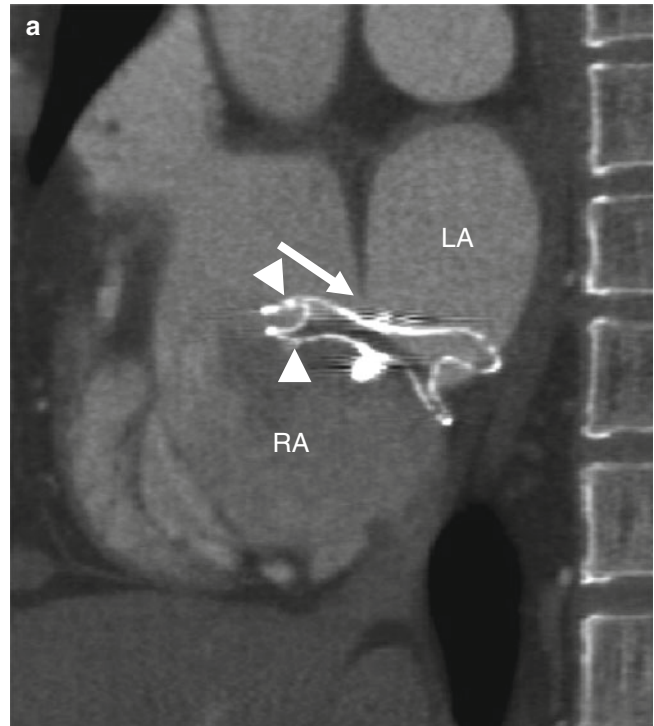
Malpositioned occluder. Minimal device protrusion is noted due to rim deficiency but no residual shunt is present. This oblique, sagittal image shows the upper portion of the AMPLATZER septal occluder device protruding into the right atrium (*RA*). Both left and right atrial disks (*arrow*) are in the right atrium. *IVC* inferior vena cava, *LA* left atrium, *SVC* superior vena cava (Reproduced with kind permission of the American Roentgen Ray Society, Leesburg, VA from Lee et al. [7])
